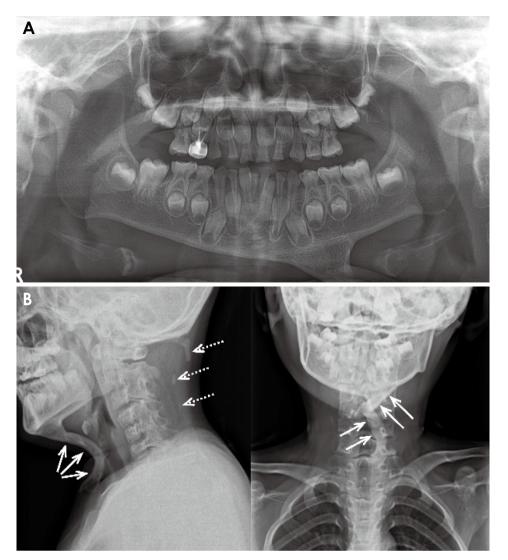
A. A standard panoramic radiograph displays heterotopic triangular ossification extending from the inferior border of the mandible. B. Lateral and anteroposterior skull radiographs depict heterotopic ossifications along the ventral (arrow) and dorsal (open arrow) neck muscles.
